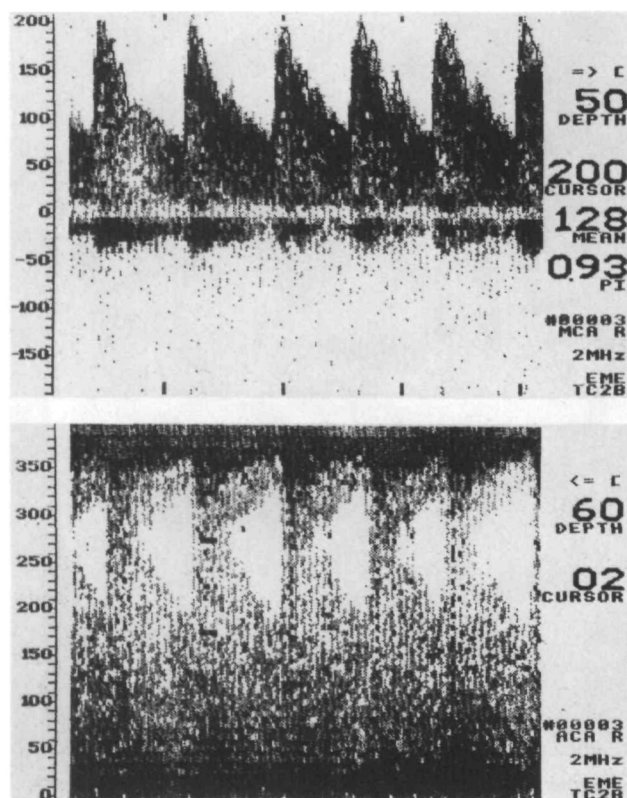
Top: Transcranial Doppler display from right middle cerebral artery (MCA) at depth of 50 mm from right temporal window; y axis, velocity in cm/sec; x axis, time in 1-second intervals. Flow toward transducer (physiologic direction) is indicated by arrow in upper right corner. Bottom: Transcranial Doppler display at 60 mm depth showing markedly elevated velocity in right anterior cerebral artery (ACA). Zero line has been moved to bottom of display to show complete velocity profile of ACA. Although systolic peaks are partly obscured by representation of blood flow from MCA in opposite direction (spectra coming down from top of display), it is apparent that peak velocity is >300 and mean velocity is $>>200$ cm/sec in proximal ACA. Flow is away from transducer, in the physiologic direction.
